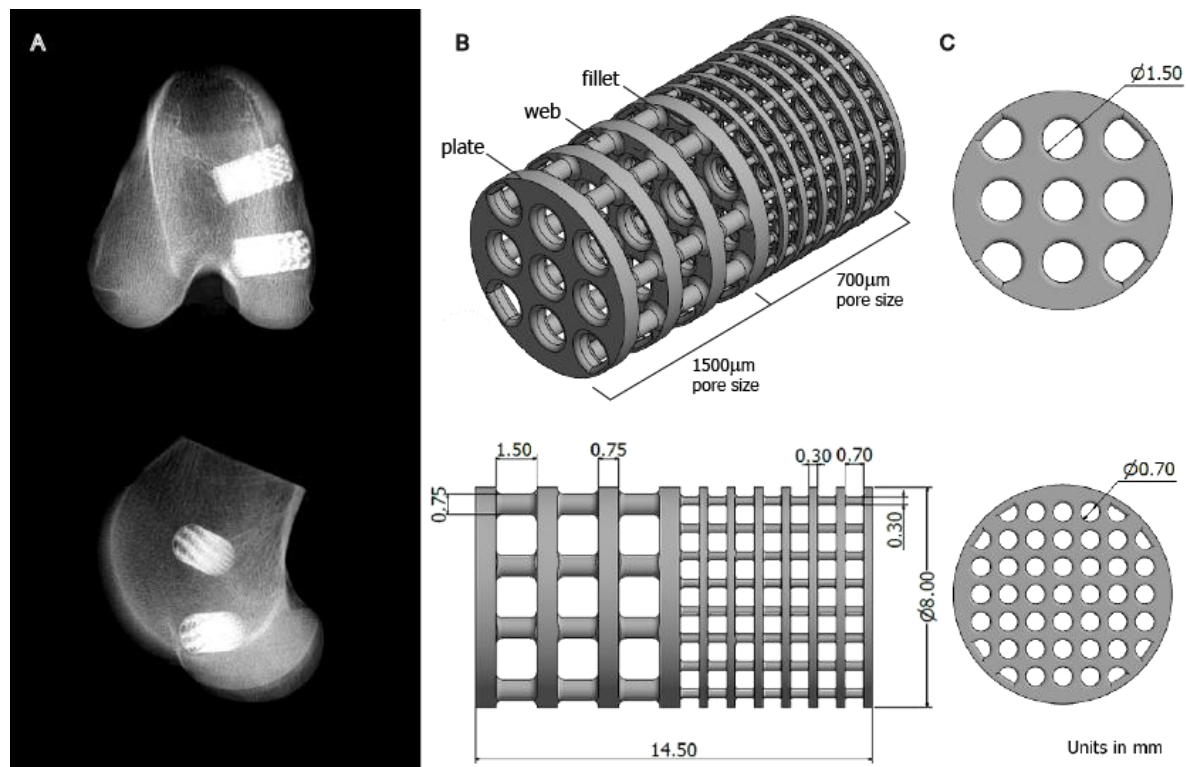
(A) Radiographs of the implanted porous scaffolds (14.5 mm length, 8 mm diameter). (B) 3D solid models. (C) Transverse cuts taken across the plates; dimensions in mm.
